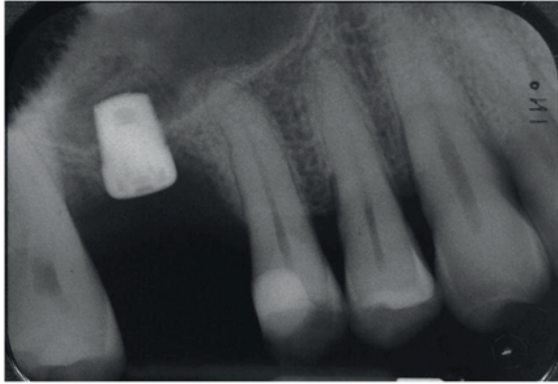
Postoperative periapical radiograph following placement of an ultra-short (5 × 5 mm) sintered porous surface (SPS) dental implant. (Malchiodi et al., 2020)
